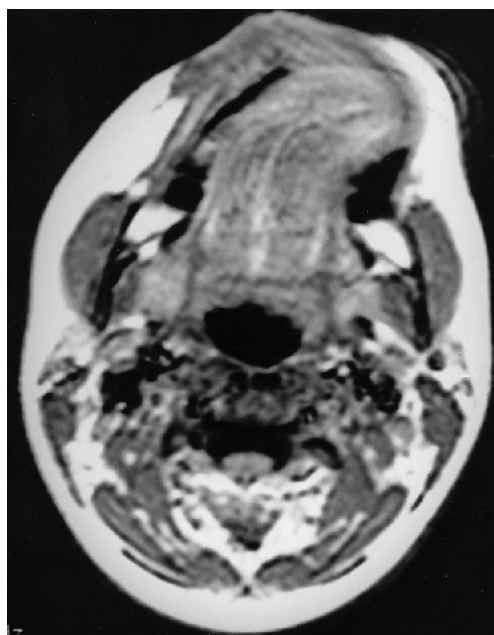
Axial MR image (500/20 [repetition time/echo time]; 256 × 128 matrix; 20-cm field of view; 1-cm section thickness) of patient shows the tongue in the left cheek. This explains the swelling noticed clinically.
